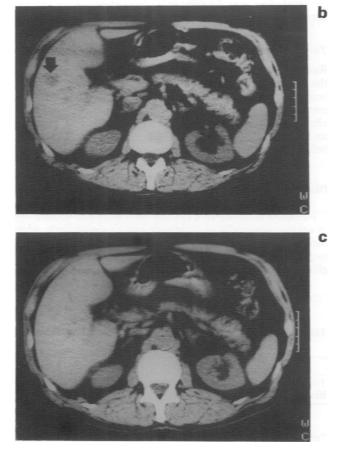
a, Partial response in size of lung metastases in patient no. 4 receiving intact A5B7 antibody. *Sum of products in two dimensions of three measurable lung metastases in plain chest radiograph. b and c, CT scan of the liver showing a liver metastasis (b) (arrowed) in patient no. 9, which resolved completely after the first course of RIT (c) with $F(ab')_2$.
